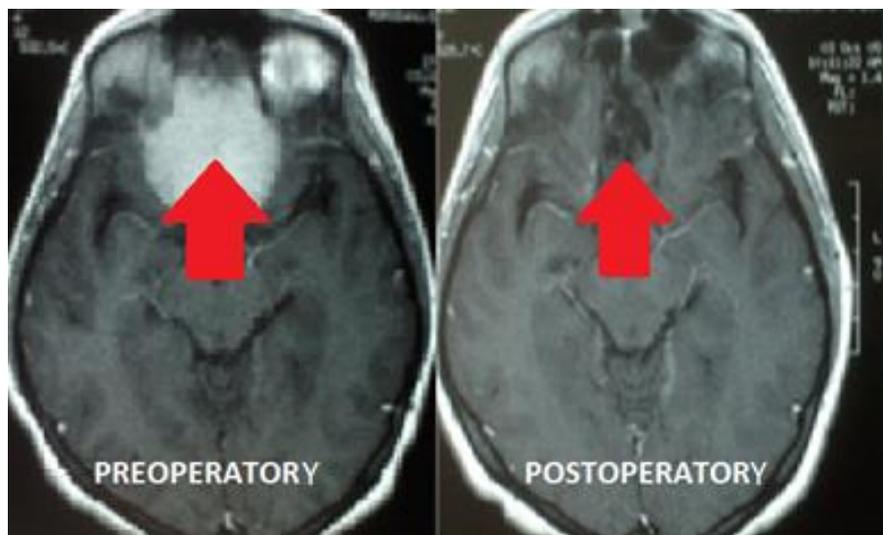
Horizontal section, MRI. Personal case Prof. A.V. Ciurea, total resection of an OGM.
